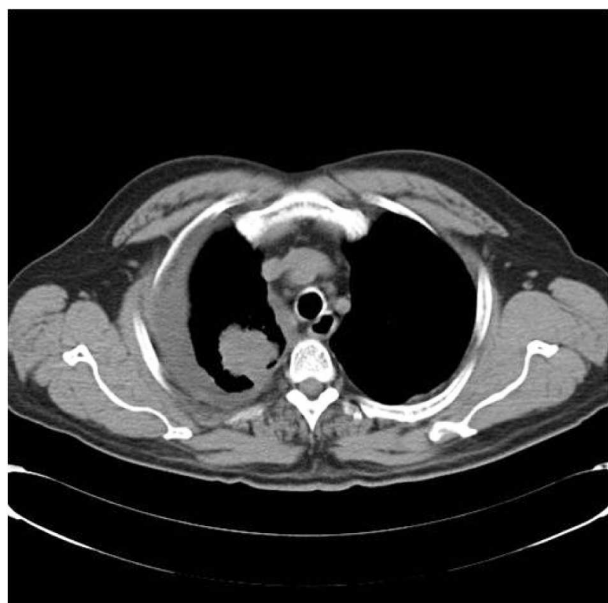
CT thorax showing the presence of a right upper lobe mass and pleural effusion
